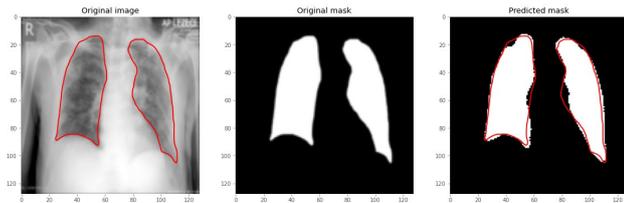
Lung segmentation using U-Net (best case scenario): (a) the original chest X-ray image, (b) manually segmented mask, and (c) automatically segmented mask of the lung
